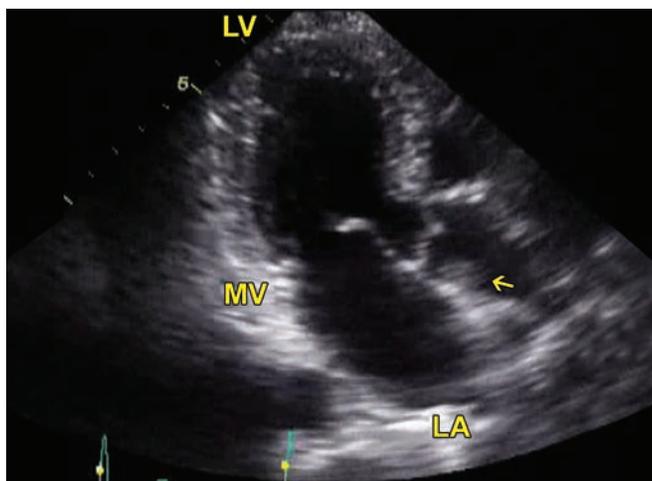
Transthoracic apical view. Arrow points to a mass in the ascending aorta.
